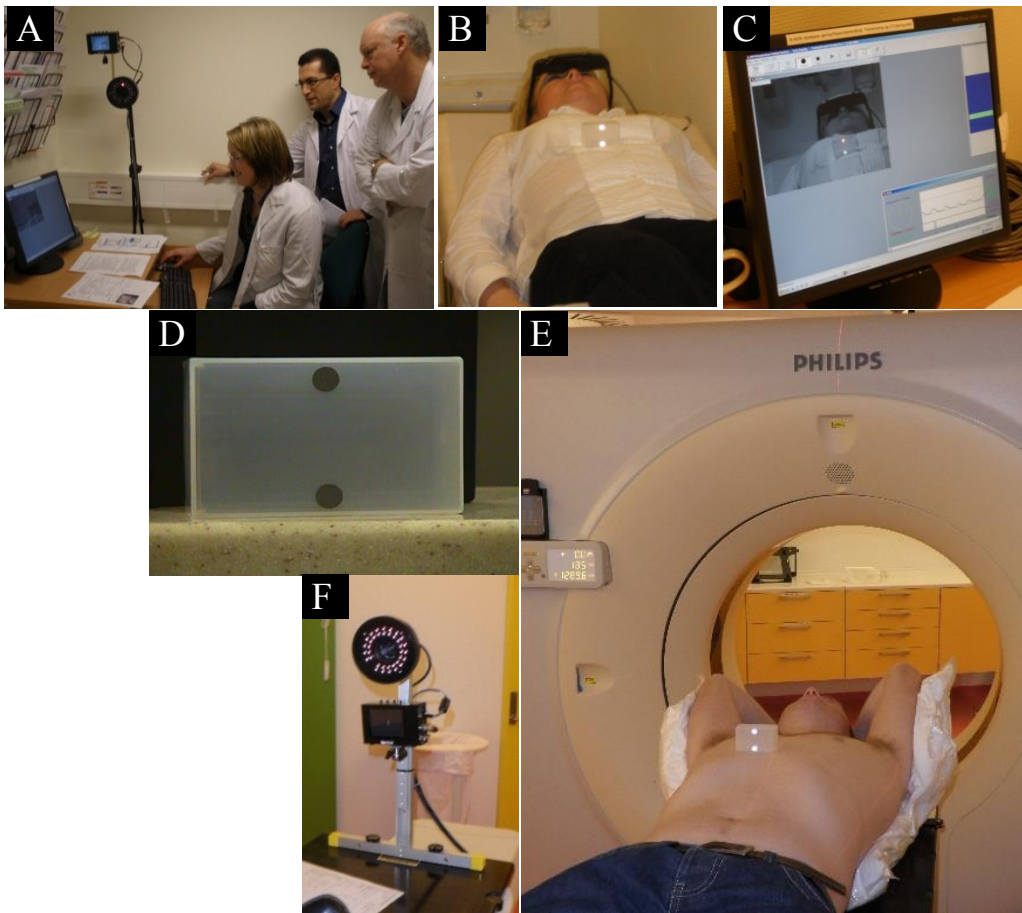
(A.) Operator during the training session. (B.) Computer goggles are used for visual guidance. The marker box is positioned on the thorax. (C.) The view of the operator. (D.) The marker box. (E.) Patient setup in an individualized fixation at the CT scanner, with the marker box positioned on the thorax. (F.) The RPM camera located at the end of the CT couch.
